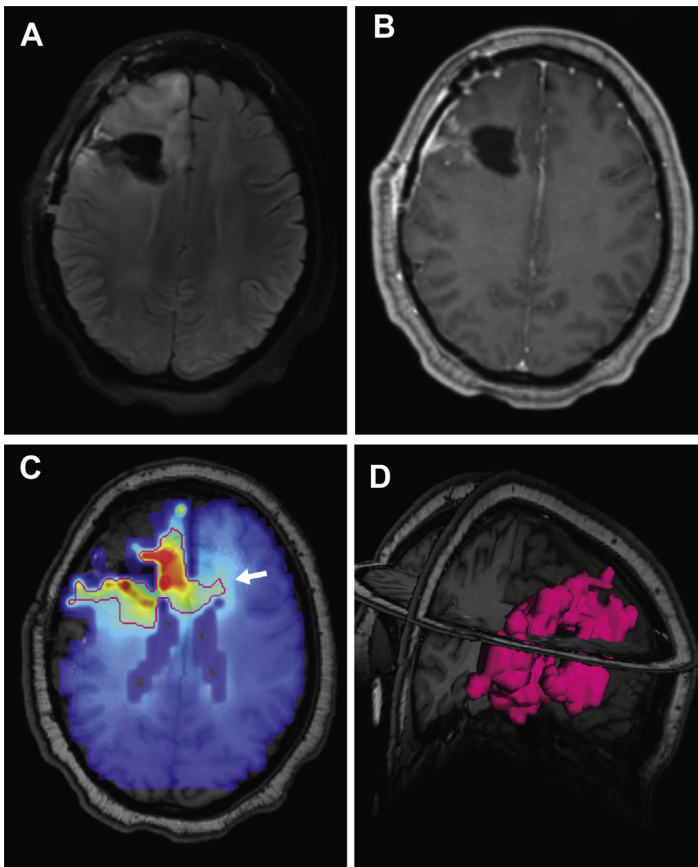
Glioblastoma. Right frontal glioblastoma, status post resection. FLAIR abnormality surrounds the cavity in the right middle and superior frontal gyri (A). A small amount of nodular enhancement is present around the cavity on postcontrast T1-weighted imaging (B). T1-weighted images overlaid with 3D Cho/NAA ratio (C) show tumor extending beyond the area of abnormal enhancement and FLAIR (white arrow). The red line outlines the area with a Cho/NAA ratio 2 times normal white matter, a threshold associated with 30% tumor in previous biopsy studies. Three-dimensional rendering of area of MRS abnormality surrounding the resection cavity (D).
